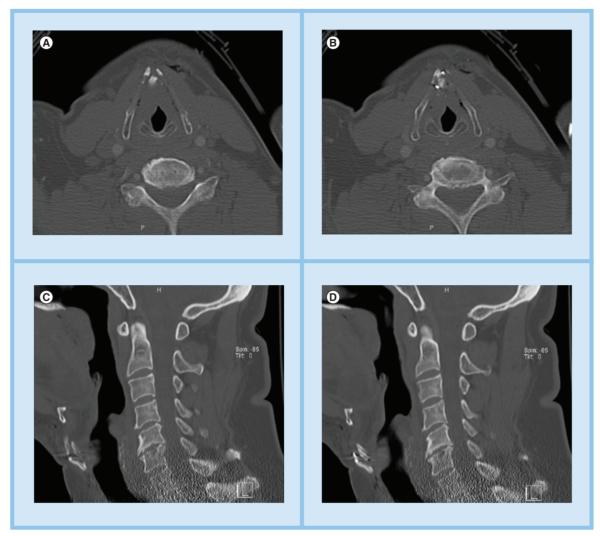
Computed tomography of the neck in a patient with a penetrating neck wound. An axial view of the neck shows (A) a comminuted fracture of the thyroid cartilage and (B) bullet fragments in the soft tissue surrounding the fractured cartilage. (C) A sagittal view of the neck also shows the fractured thyroid cartilage and (D) air in the soft tissue at the entry point around the thyroid cartilage.
